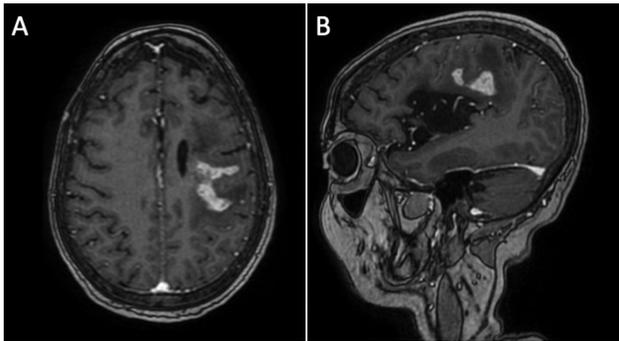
Magnetic resonance imaging of brain in axial (A) and sagittal (B) section in T1-weighted sequence with presence of expansive lesion with hyposignal and heterogeneous enhancement by gadolinium.
